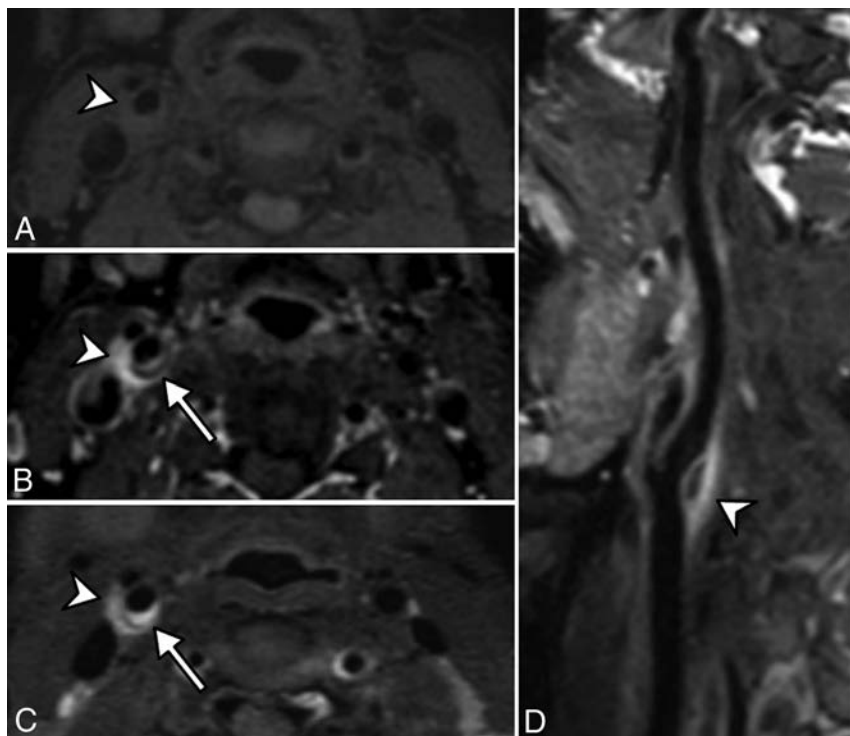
Pre (A) and post (B) contrast fat-suppressed 3D T1 and 3D T2-weighted (C) MR imaging in an axial plane shows T1 hypointense and T2 hyperintense perivascular infiltration (arrowhead) at the level of the carotid artery bifurcation, enhanced after gadolinium injection. A distinct soft intimal plaque (arrow) is visible at the posterior part of the carotid artery. A sagittal curvilinear reconstruction of the right internal carotid artery on the postcontrast T1-weighted imaging (D) shows the PVI (arrowhead) centered at the level of the right carotid artery bifurcation and extended to both the distal common carotid artery and proximal internal carotid artery. Note that there is no vascular or perivascular abnormality involving other parts of the common or the internal carotid arteries.
